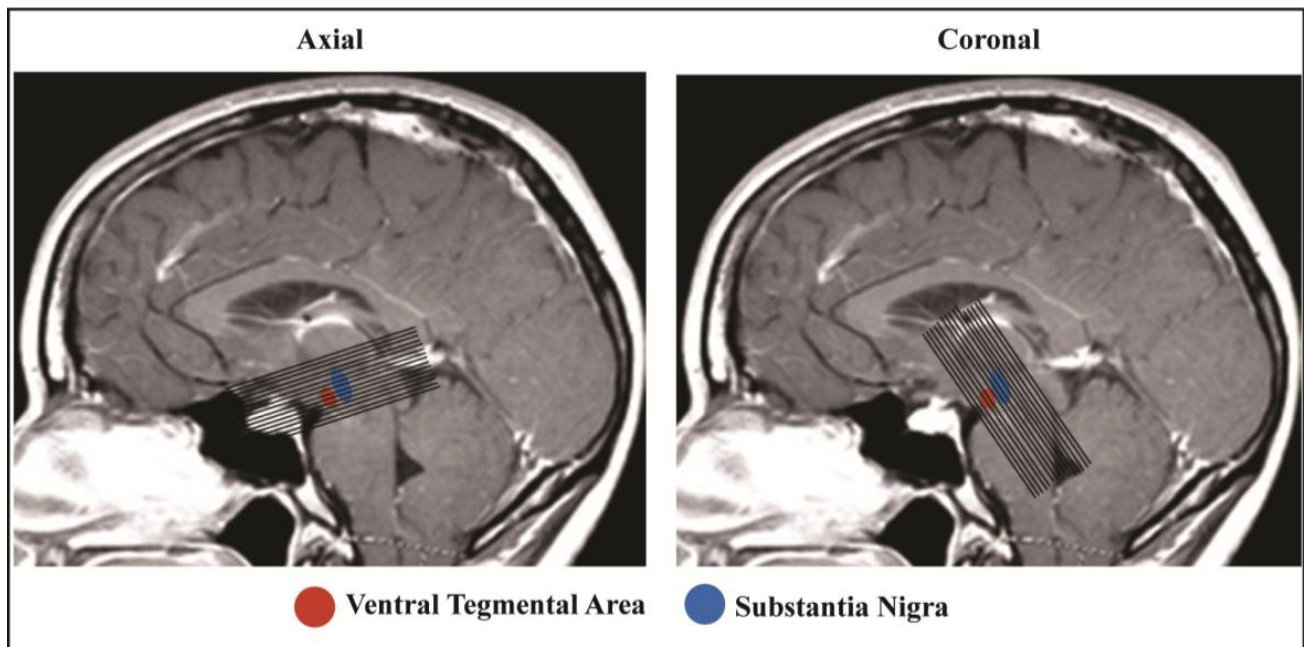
Slice positioning for anatomical midbrain imaging overlaid on mid sagittal MR images. The left panel shows slice coverage in the axial plane (horizontal slice slab) and the right panel shows the slice coverage in the coronal plane (vertical slice slab). The VTA and SN are represented as red and blue solid circles respectively underneath the slice stack. A denotes the anterior part of the brain. (Coster 2012).
